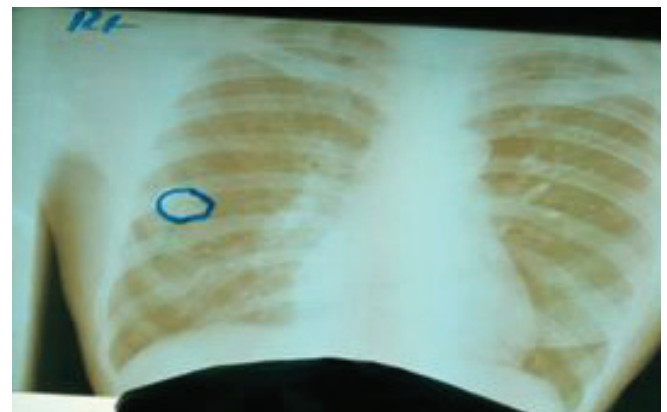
Case 3. X-ray with remaining coin like lesion (Credit: Kizza Paul and Paula Nuer)
